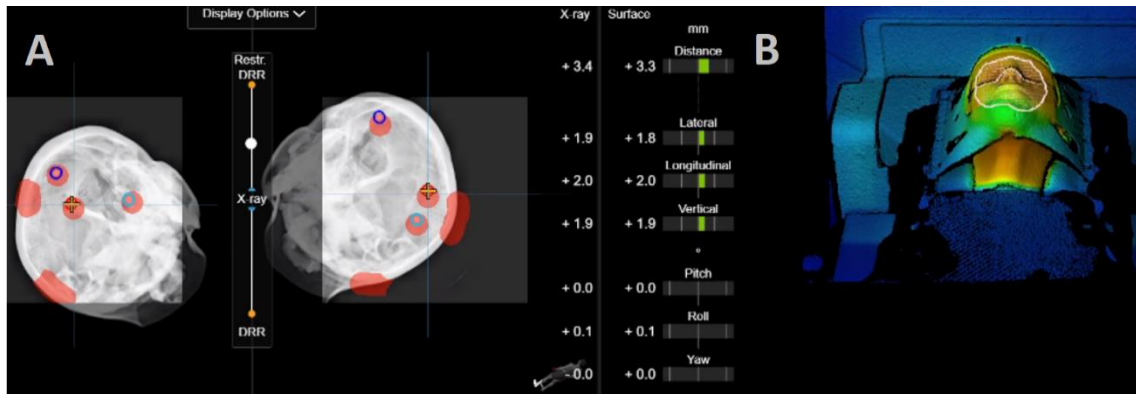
(A) Combined imaging modalities in the EXT-D system: (A) stereoscopic X-ray imaging, (B) surface optical/thermal imaging [88]. Figure reproduced with permission by John Wiley and Sons.
